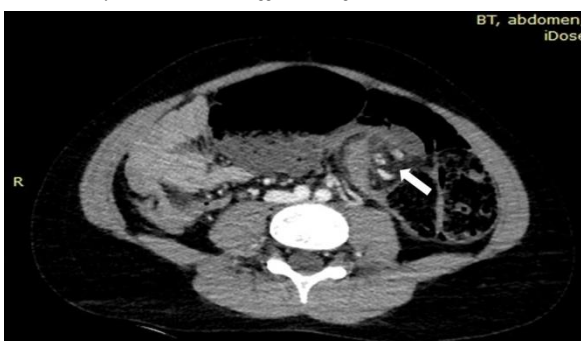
Axial abdominal CT image showing a distended gas-filled colonic loop and the whirlpool sign (twisting of the mesentery and vessels: arrow) suggestive of sigmoid volvulus.
